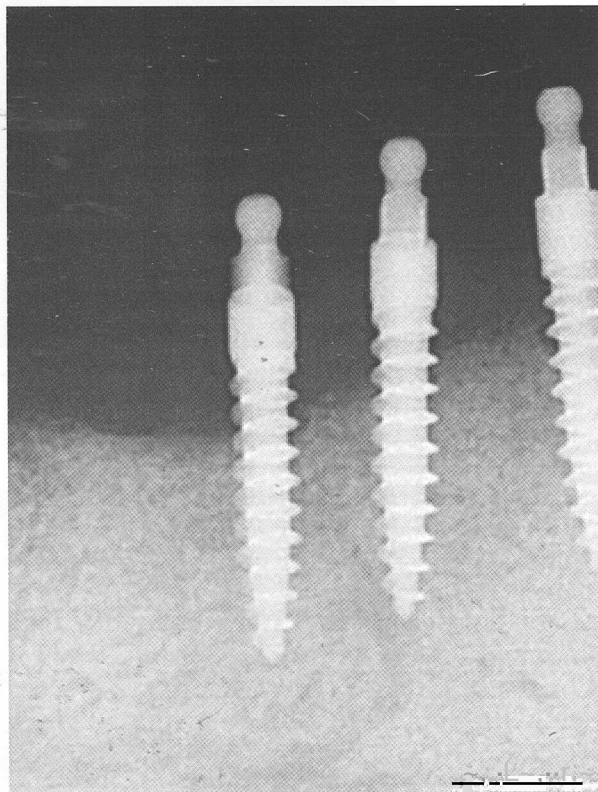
Periapical radiographs of lower right quadrant taken immediately after mini implant placement.
